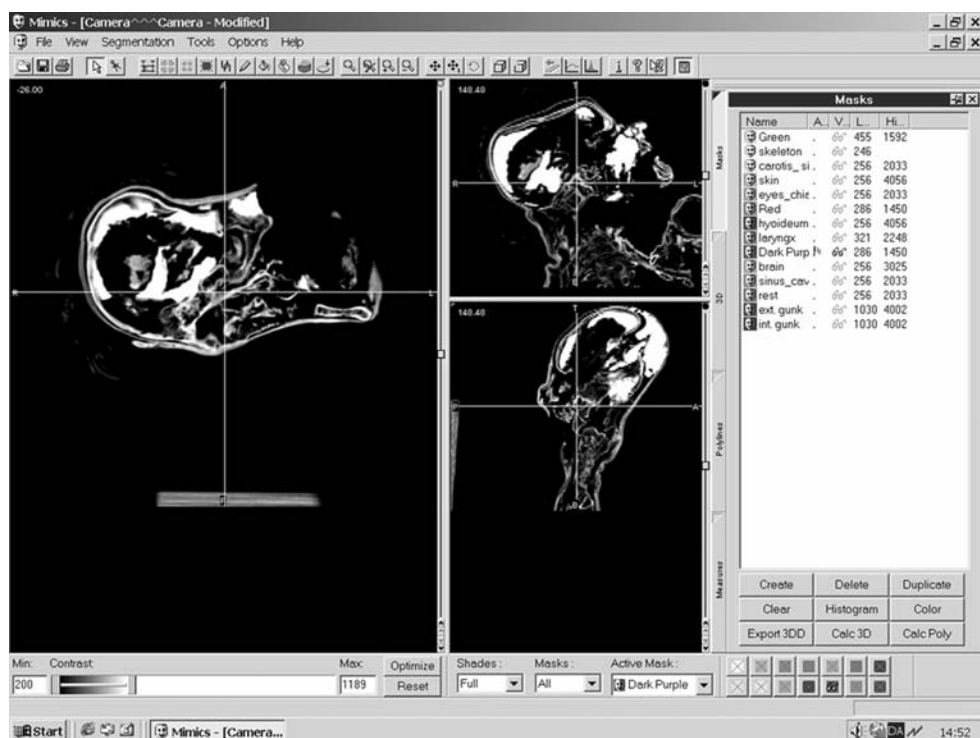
Program interface of MIMICS® showing a CT slice image being segmented by application of 'masks' (colour coding) based on thresholding of the grey-scale values
